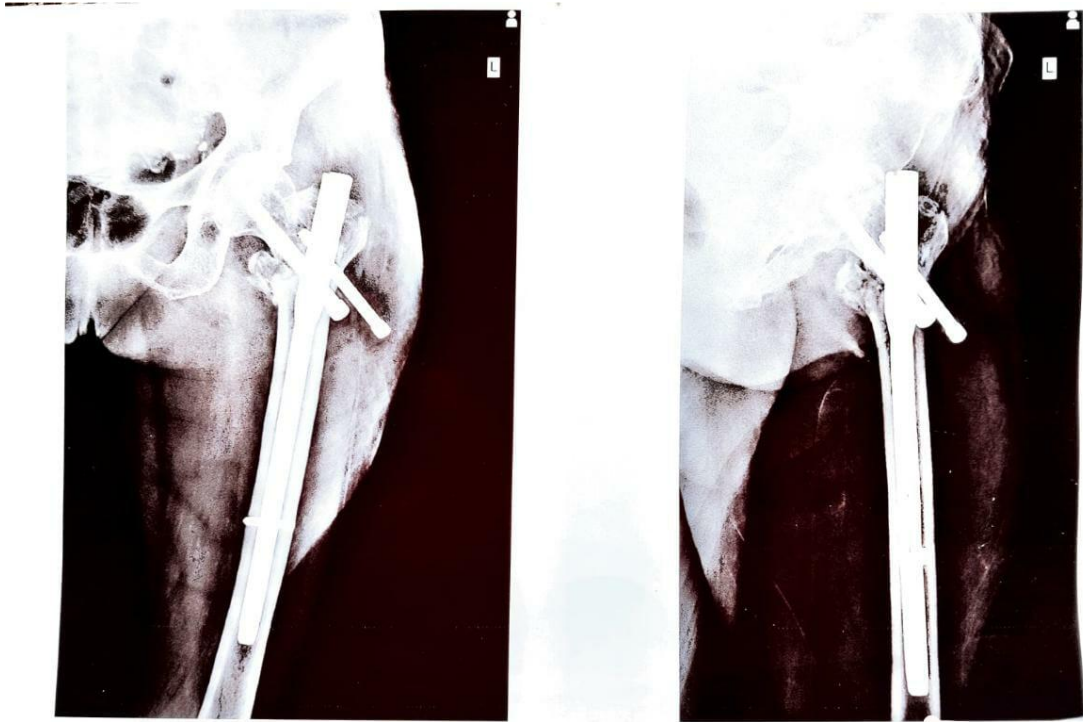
PostOperative X-ray
